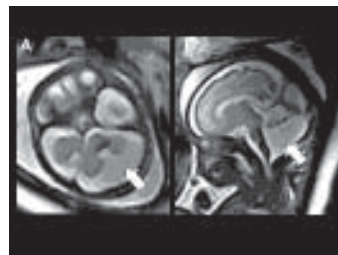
A&B, Fetal MRI of Dandy- Walker malformation. Axial MRI section shows fourth ventricle communicating with cisterna magna, and the cerebellar hemispheres appear hypoplastic. Sagittal section reveals enlarged posterior fossa. The vermis is hypoplastic and is seen only in superior aspect in this midline section.
